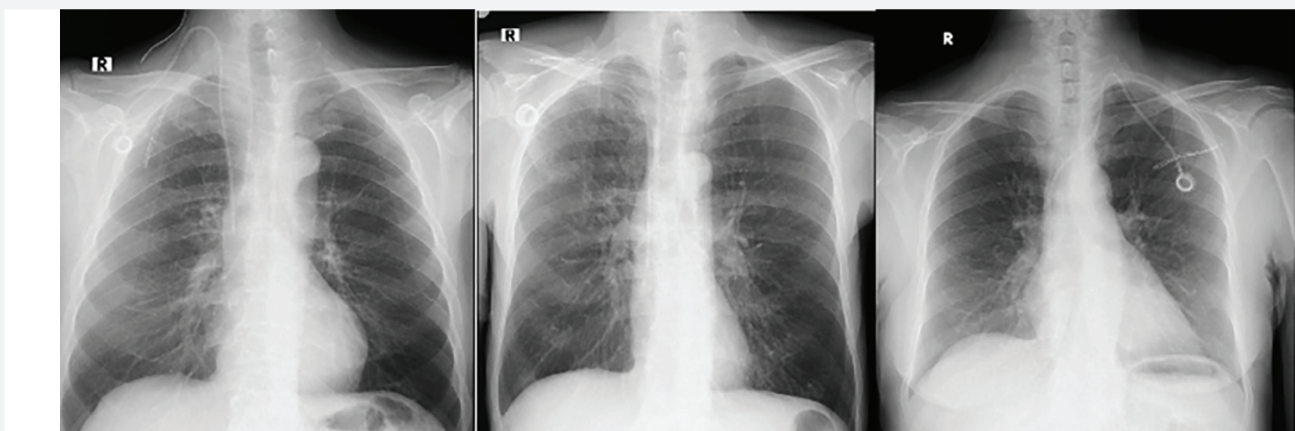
Chest radiography in the postoperative period; right jugular vein, right subclavian vein and left jugular vein, respectively
